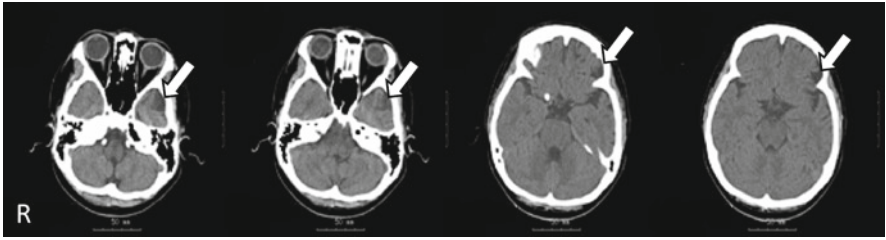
CT findings of case DR
